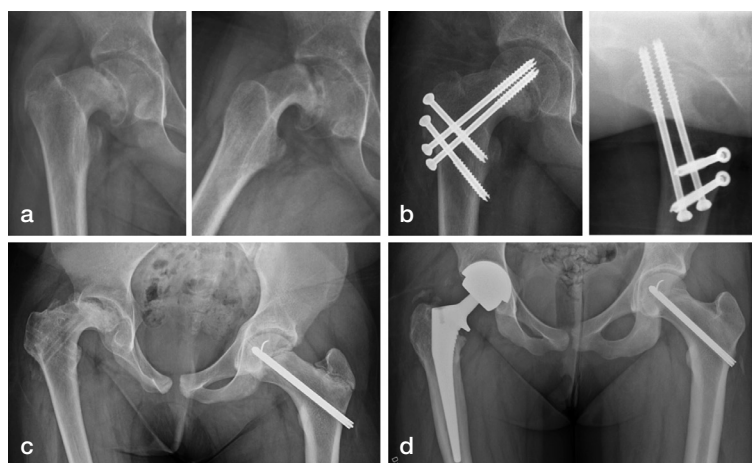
Radiographs (a) of a 12-year-old girl with a 7-month history of hip-related symptoms show a severe, stable right-sided SCFE (slip angle 72°). The girl underwent capital realignment using the modified Dunn technique as primary treatment (b). The patient developed avascular necrosis, and the screws were removed (c). The hip was converted to a THA 16 months after the modified Dunn (d).
